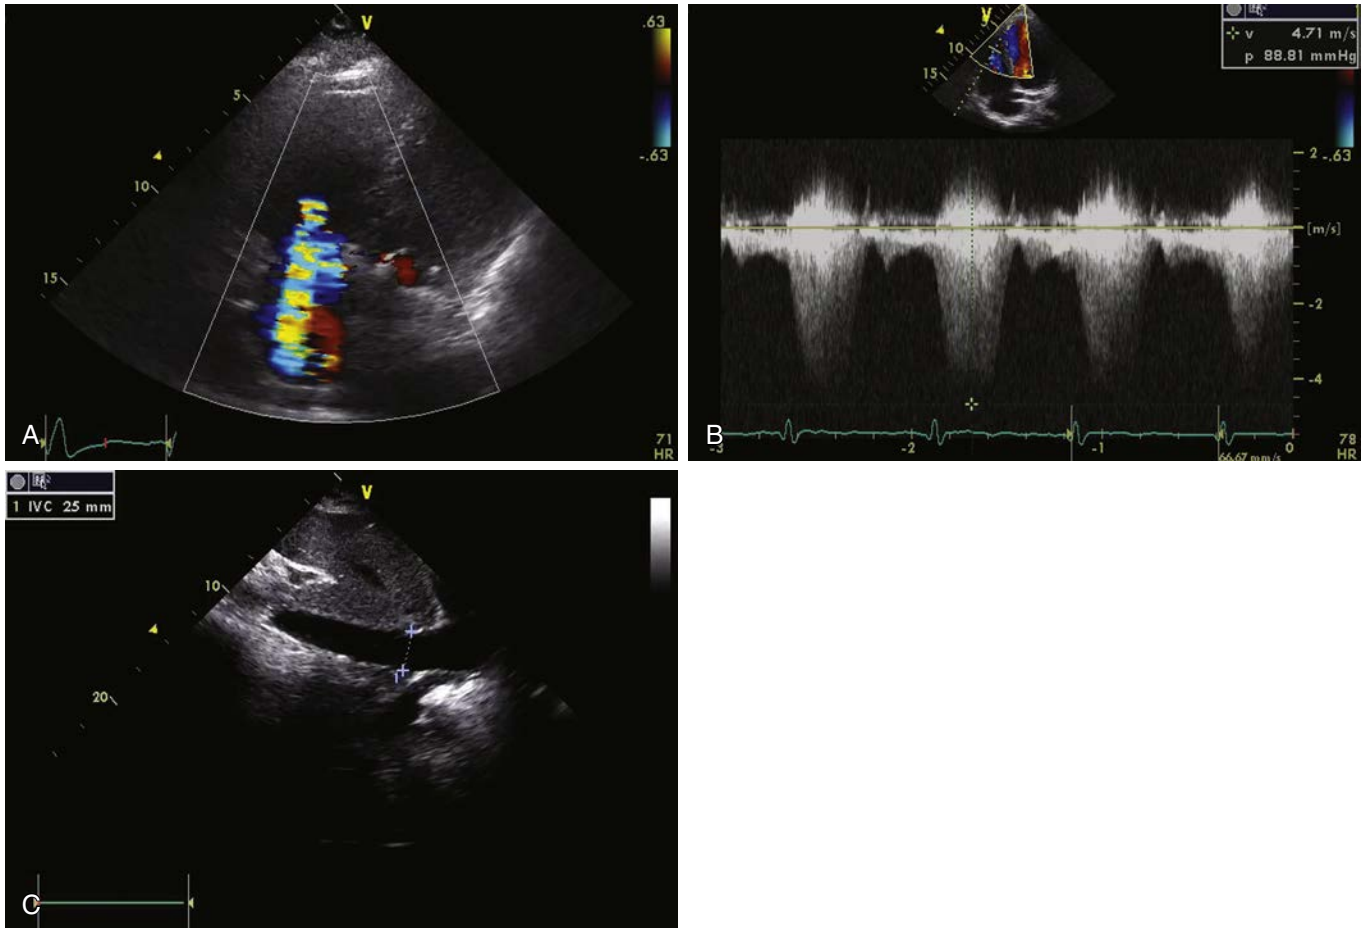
Tricuspid regurgitation (TR). (A) Transthoracic echocardiography apical four-chamber view showing severe TR associated with right ventricular (RV) dysfunction. (B) The TR maximum pressure gradient was 88 mm Hg. (C) The inferior vena cava (IVC) is dilated, for estimated right atrial pressure of 10 mm Hg and RV systolic pressure of 98 mm Hg.
